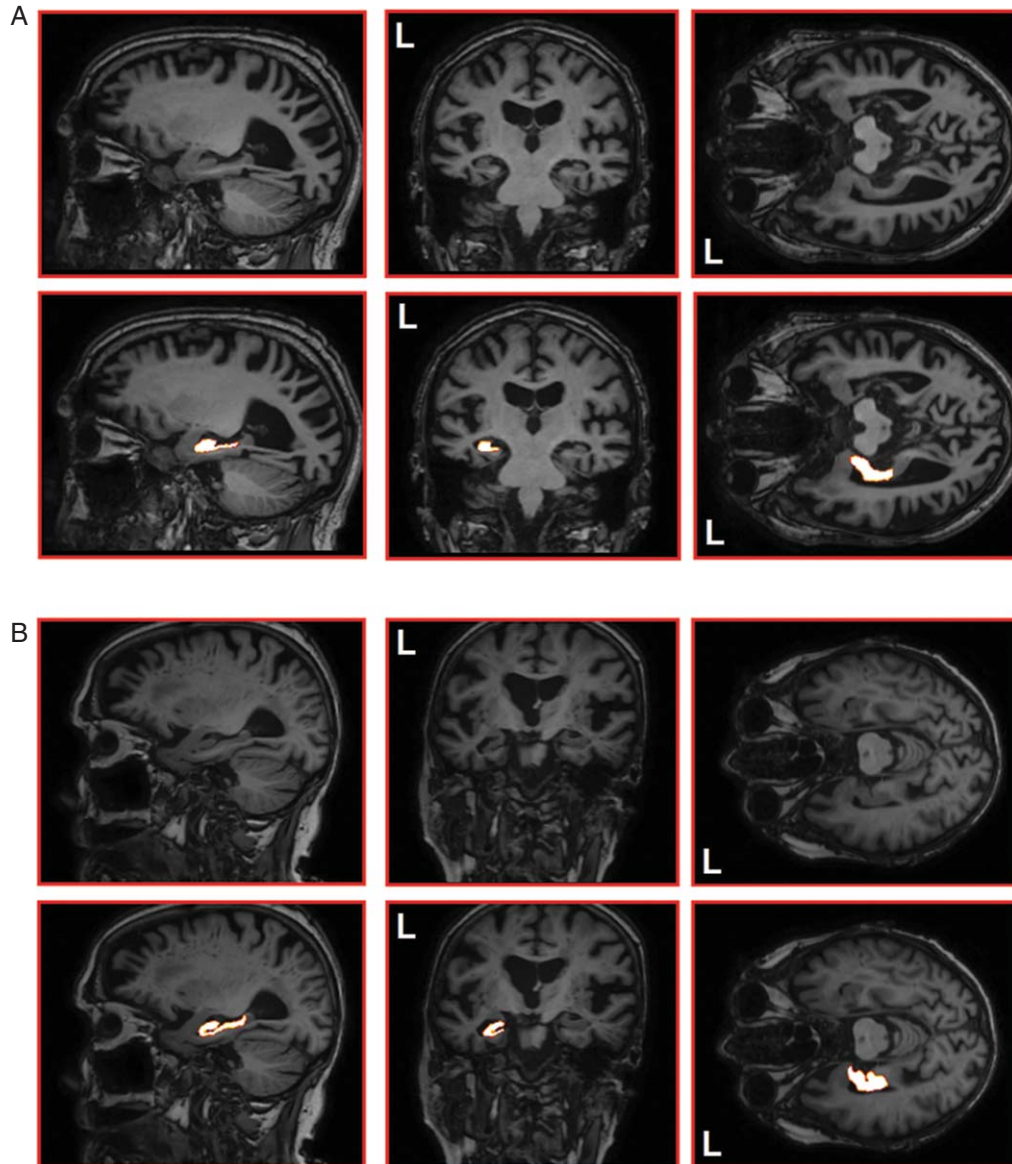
Two examples of hippocampal segmentation using STEPS. Hippocampal volumes were calculated based on the T1-weighted image in its native space. These two examples show the segmentation of the left hippocampus of a patient with AD dementia (A) and a healthy control (B). Slices are shown with and without the hippocampal overlay.
